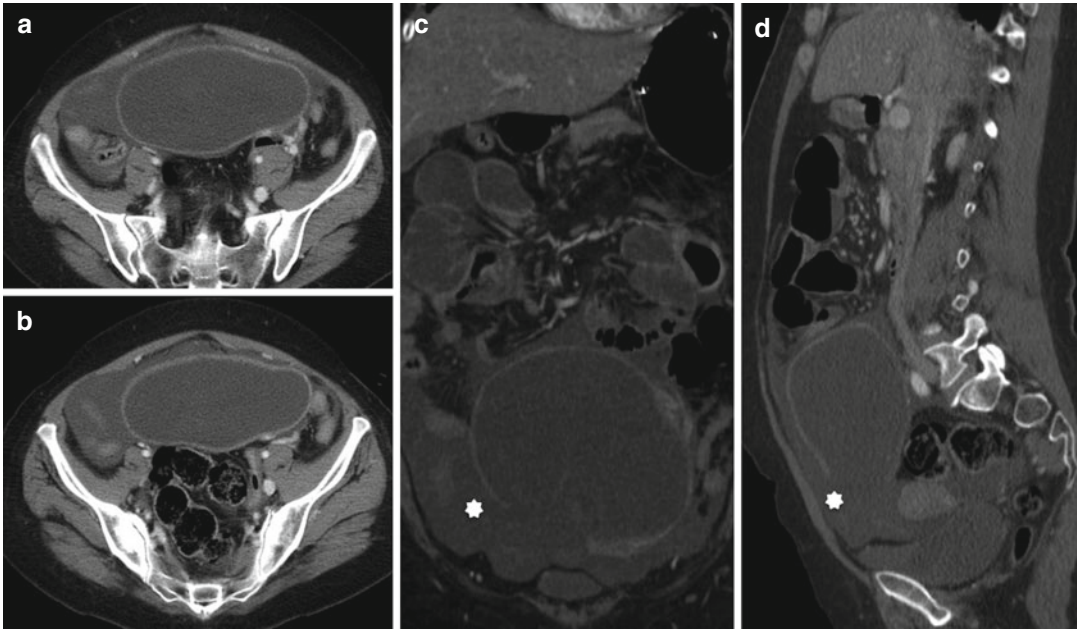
Multiplanar contrast-enhanced CT images in a surgically confirmed twisted serous cystadenoma. (a, b) The axial images show a large cyst with high-density fluid
